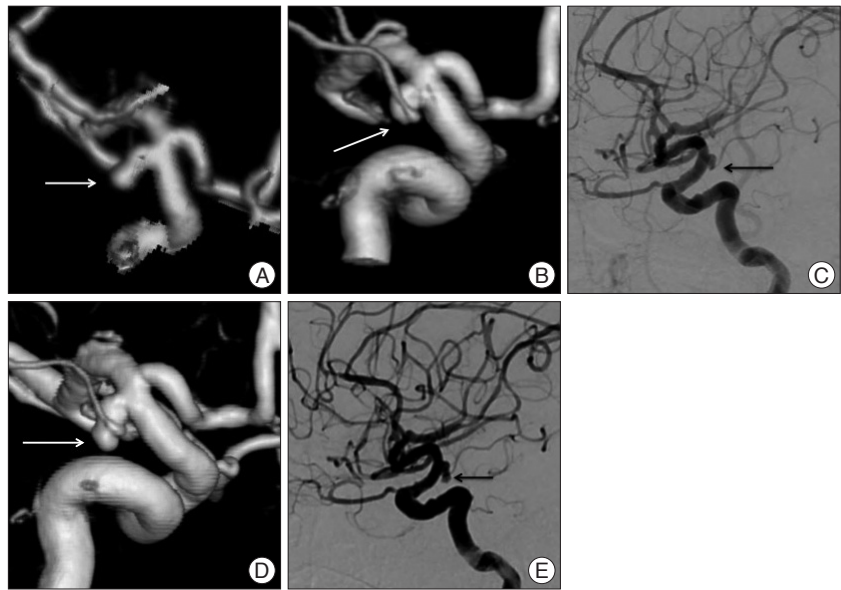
Brain 3-dimensional computed tomographic scan (A) reveals left anterior choroidal artery aneurysm, 3×6 mm in size (white arrow). Rotational angiography (B) and left lateral internal carotid artery angiography (C) shows a partial thrombosis of the distal part of the aneurysm (black and white arrow) compared to the findings of previous angiography. Follow up angiography (D and E) 7 days later demonstrates recanalization of the thrombosed aneurysm (black and white arrow).
